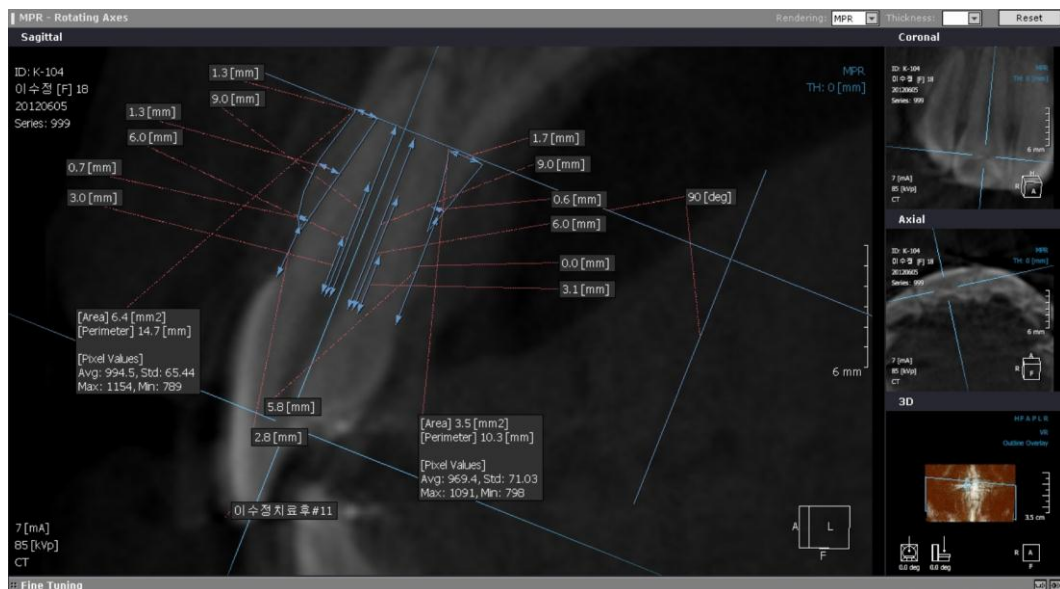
CBCT analysis of #11 after Treatment ( T2 )
